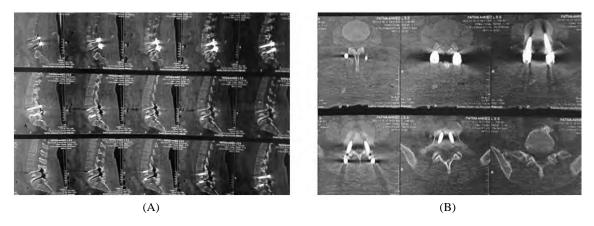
Case (1): Postoperative CT lumbosacral spine showing transpedicular fixation by screws with posterollateral bony fusion sagittal view (A) Axial view (B).
